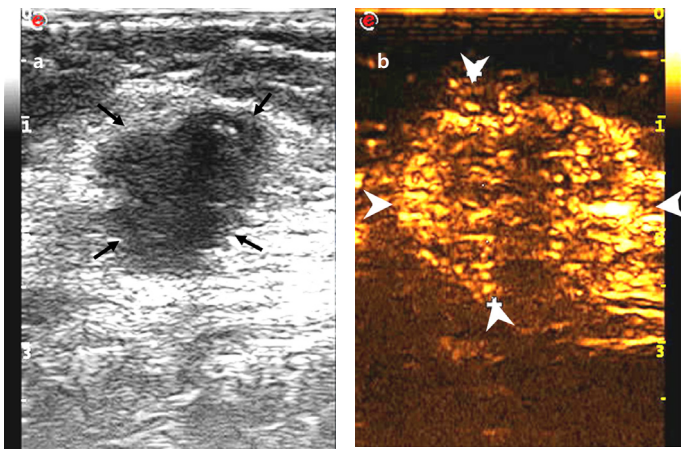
Images of a 55-year-old female diagnosed with invasive ductal carcinoma in the right breast: (a) tumor with a maximum diameter of 2.0 cm showed a non-circumscribed margin on the conventional ultrasound (thin arrow), and no suspicious axillary lymph node was present; (b) tumor with an extended range of 2.6 cm showed a clear boundary, and vessel perforation (thick arrow) in surrounding tissue or mass was absent. Non-node metastasis was found in the final pathological results.
